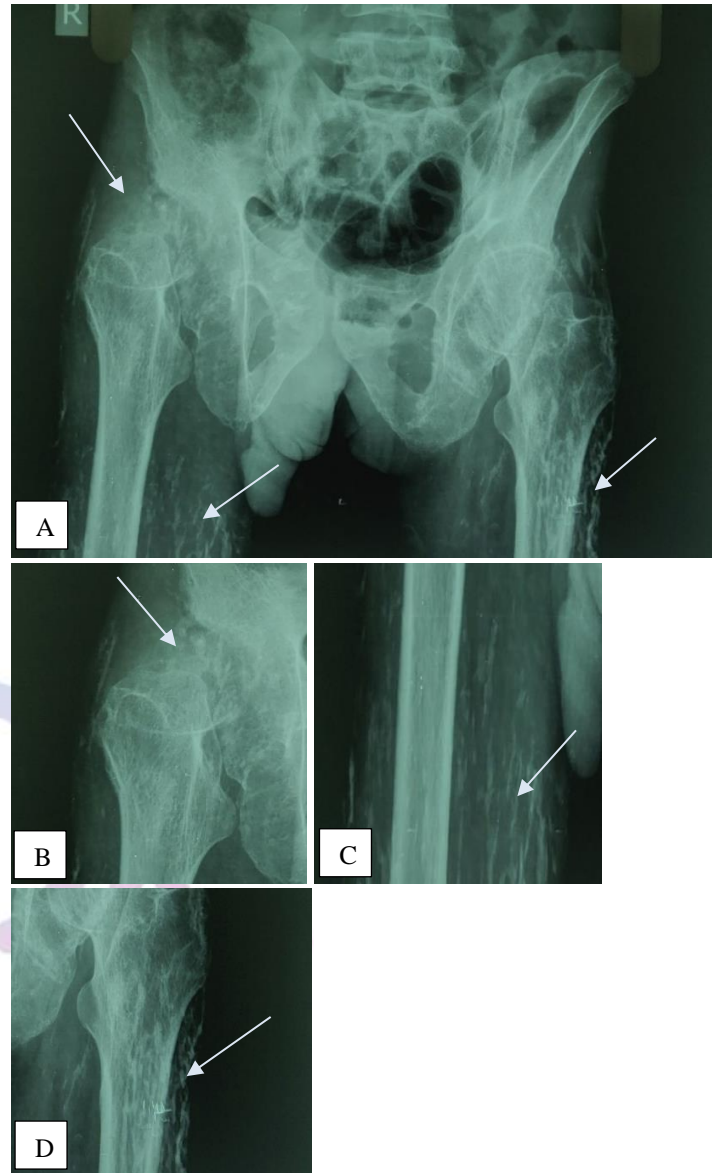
A. X-Ray PBH - Calcified deposition in soft tissues with degenerative changes in right hip joint showing resorption of right head of femur (grey arrows). B. Zoom view of X-ray PBH showing degenerative changes in right hip joint and resorption of right head of femur (grey arrows). C. Zoom view of X-ray right thigh showing calcific deposits in soft tissue (grey arrow). D. Zoom view of X-ray left thigh showing calcific deposits in soft tissue (grey arrow).
